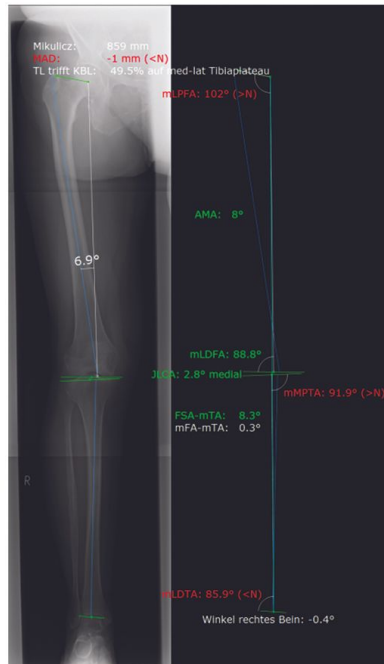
Preoperative planning using a full leg radiograph.
